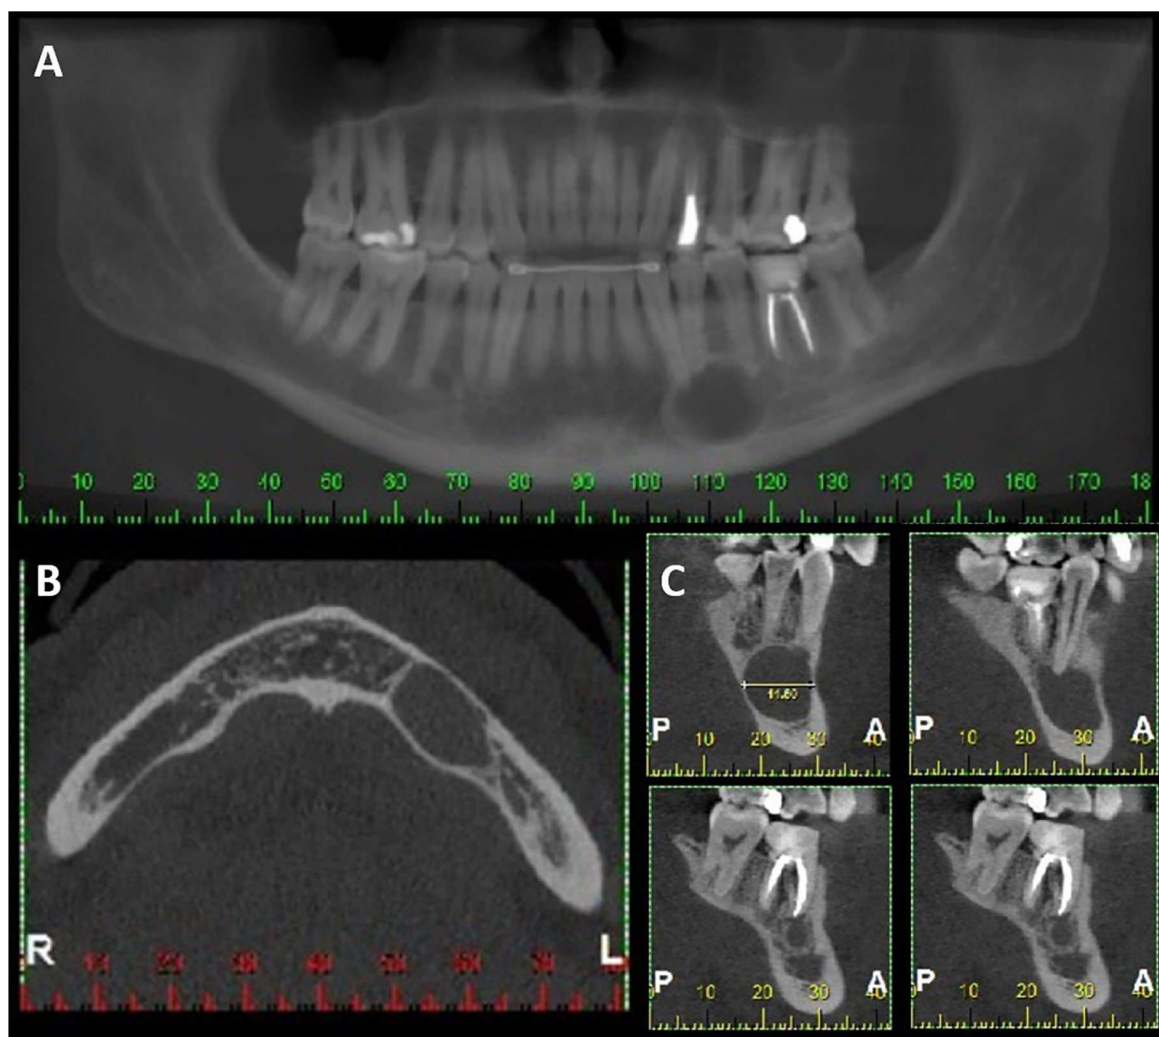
Cone beam computed tomography. (A) Panoramic reconstruction, (B) axial cuts, showing a well-circumscribed hypodense lesion, causing discrete bulging of the lingual cortical mandibular bone, (C) sagittal cuts, showing a well-defined hypodense cystic lesion.
